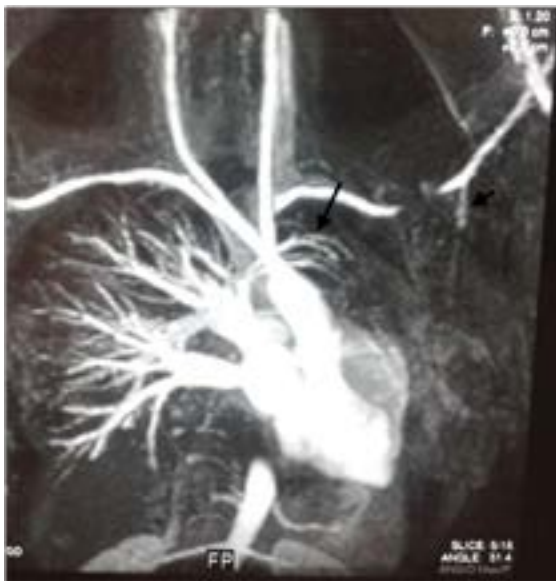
Computed tomography demonstrates the absence of the left pulmonary artery (in circle).
